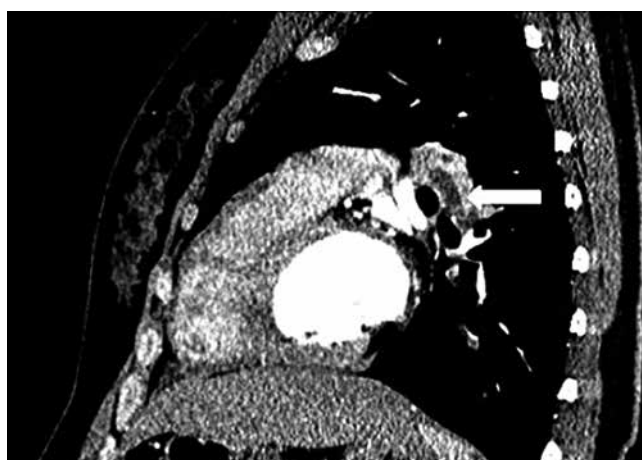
Pulmonary CT angiography – the image presents the emboli on the left side – on the level of left pulmonary artery division.
